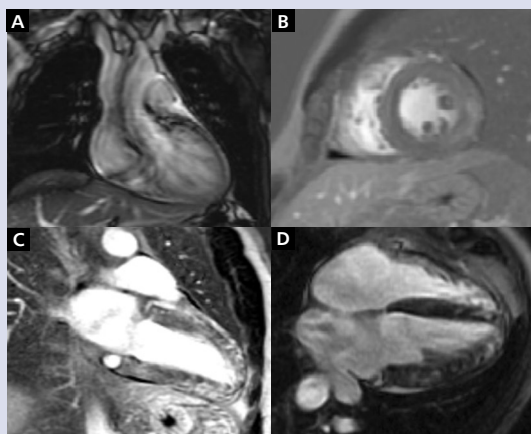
Cardiac magnetic resonance images; A. Cine sequence showing anatomy and left ventricular systolic function; small pericardial effusion is seen; B. Late gadolinium enhancement (LGE) — short-axis projection; C. Long-axis imaging, sub-epicardial and intramuscular LGE areas particularly prominent within the ventricular septum and the posterior wall; D. Four-chamber projection
